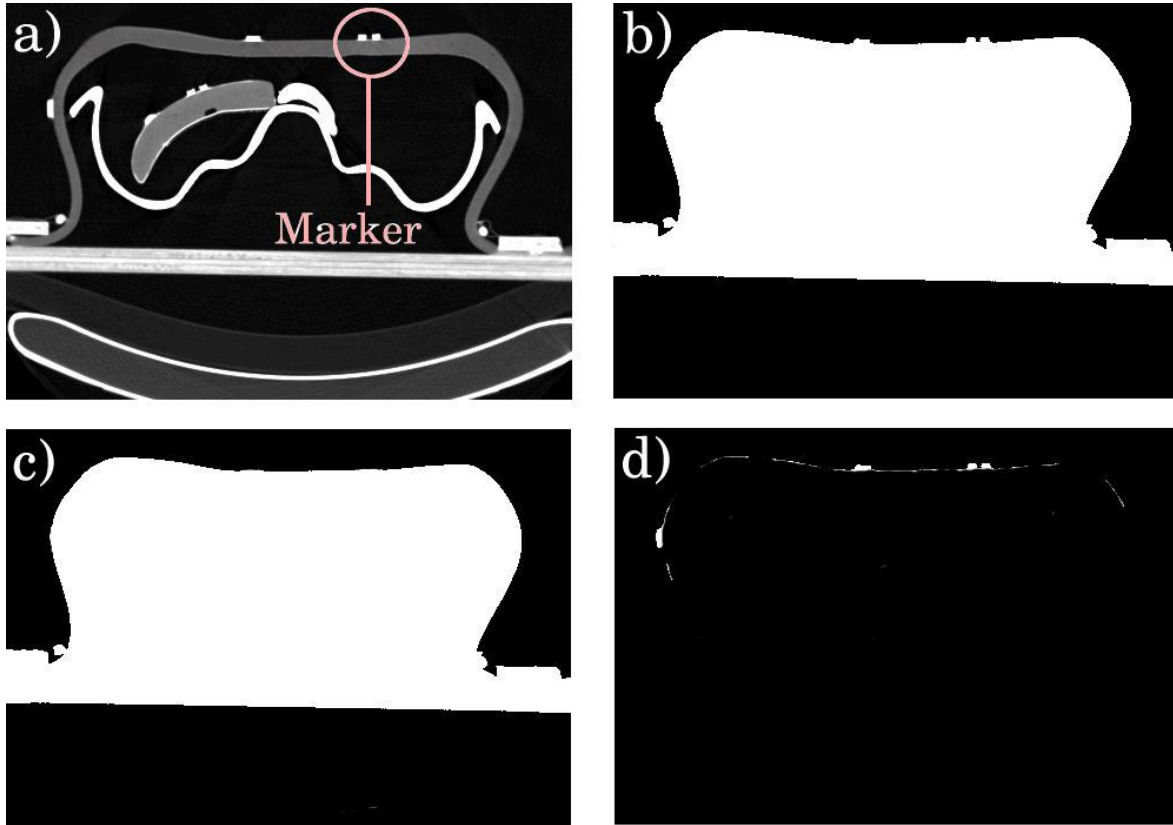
a) Original CT-slice. A radio-opaque marker is circled. b) Original image after the thresholding and the filling. c) Opening of the largest component. Markers have disappeared. d) Subtraction of image (c) to image (b) provides the markers.
